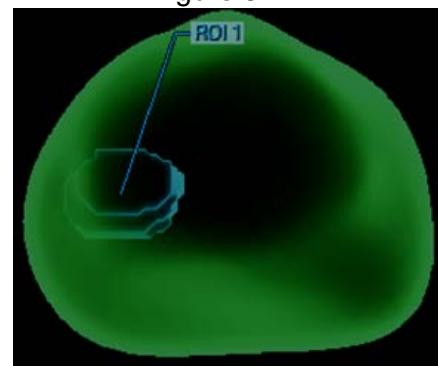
Three-dimensional rendering of the prostate utilizing the RSI-MRI then DynaCAD software for targeted prostate biopsy with Gleason 3+4 cancer.
